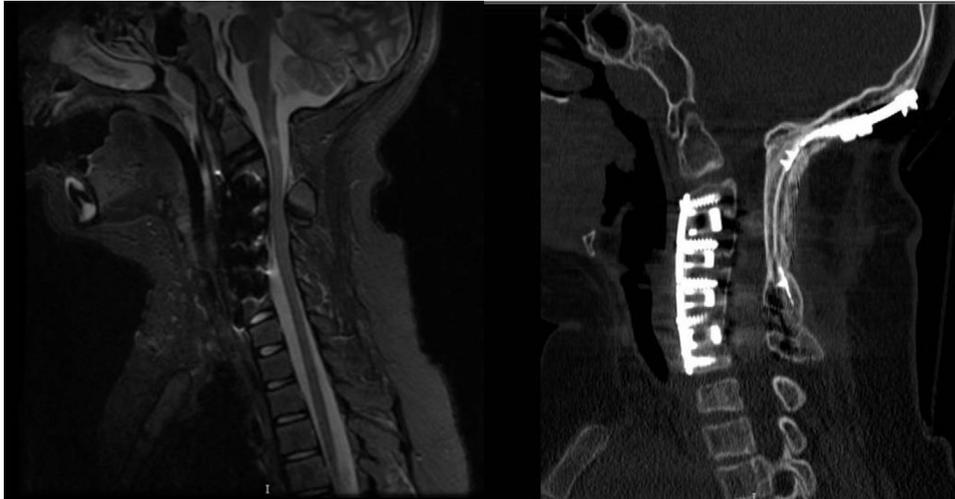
Postoperative stage 1 sagittal magnetic resonance imaging and 6 month postoperative computed tomography scan images. Bone fusion obtained from occiput to C7. Stage 1 anterior C3–C7 discectomy and fusion followed by stage 2 C3–C4 laminectomy and fusion of occiput to C7.
